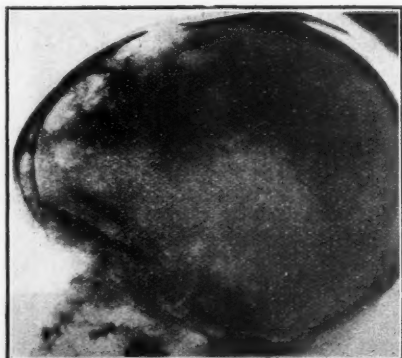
Skiagram of skull showing metastatic sarcoma in a child (from Holmes and Ruggles; "Roentgen Interpretation.")
